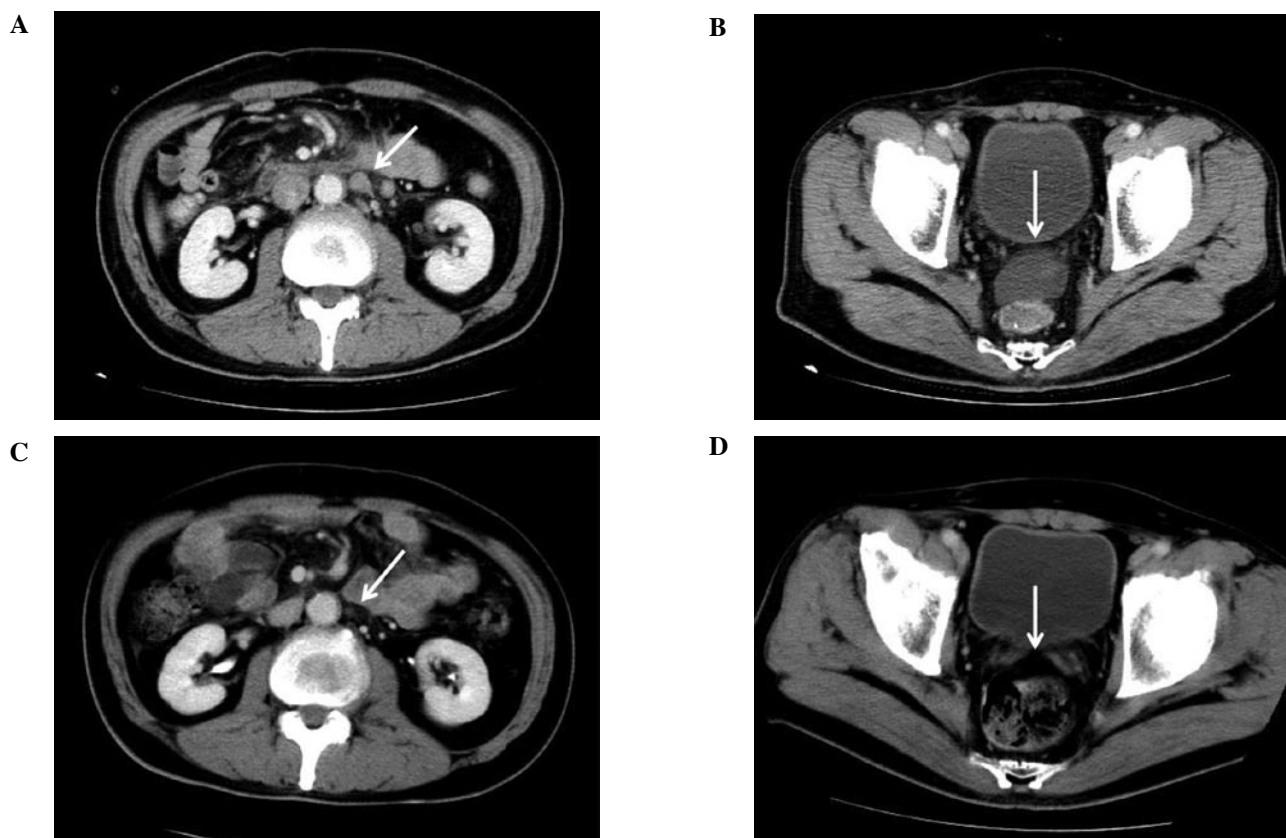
(A) Abdominal CT showed multiple lymph nodes metastases including a para-aortic region indicated by the white arrow. (B) A small amount of ascites was present in the pelvic cavity. (C) After chemoradiotherapy, the lymph nodes showed downsizing. Clinical efficacy was evaluated as PR. (D) Ascites disappeared after chemoradiotherapy.
